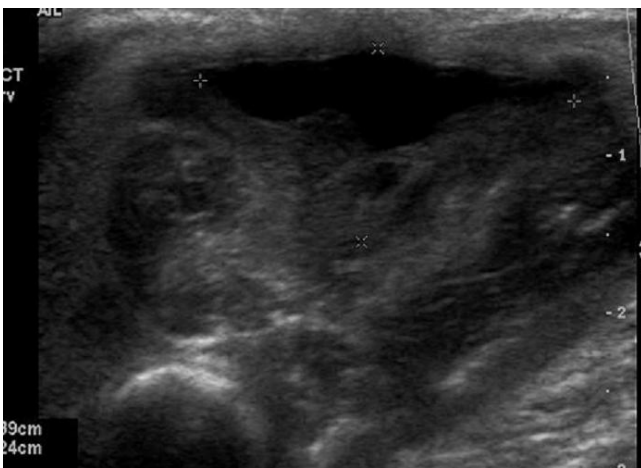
Ultrasonography shows echogenic fluid collection in deep subcutaneous & muscular layer.
